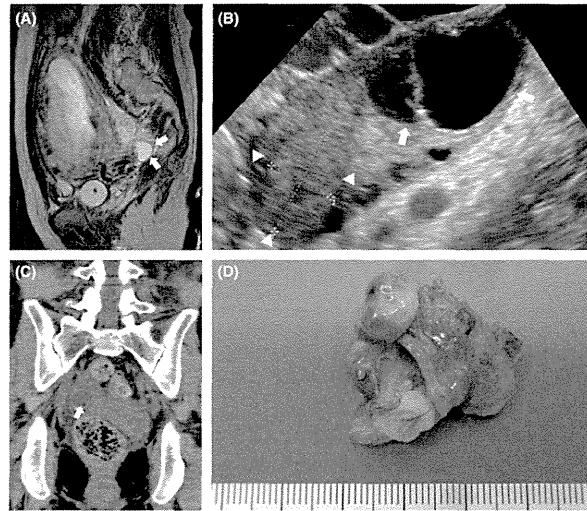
(A) T2-weighted magnetic resonance images of the pelvis in the sagittal plane at 16 weeks of gestation. A cystic mass (arrows) was found in the right adnexa. A lipid component could not be detected. (B) High-resolution transvaginal ultrasonography of the right ovary. A cystic mass (arrows) was detected next to the corpus luteum (arrowheads). (C) Noncontrast computed tomography with adaptive iterative dose reduction of the adnexal area was performed at 16 weeks of gestation. A tiny lipid component (arrow) was detected in the adnexal mass. (D) Macroscopic findings of the right ovarian tumor. The tumor measured $10 \times 25 \times 30 \text{ mm}^3$ and contained adipose tissue and hair.
